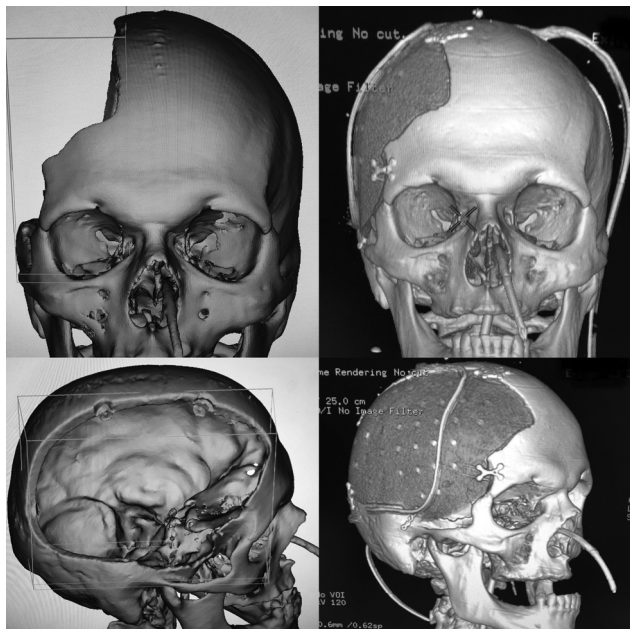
Pre- and post-operative 3D computed tomographic scans of hemi-craniectomy patient who underwent cranioplasty with customized cranial implant.
